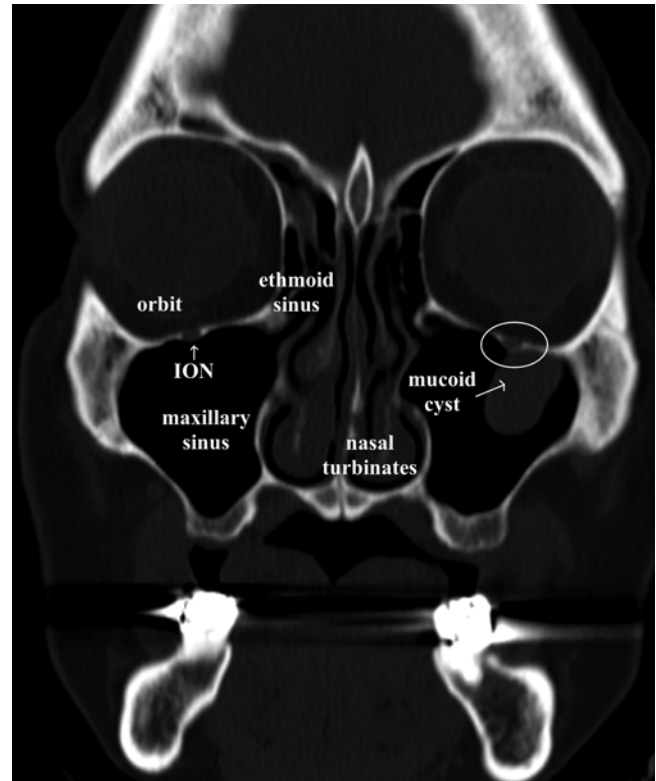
Coronal CT image showing the location of the infraorbital nerve (ION) in relation to the maxillary sinus. Note the intra-sinus mucus cyst on the left, incorporating the infraorbital nerve (circled) (Image courtesy of Andrea Trescot, MD)
